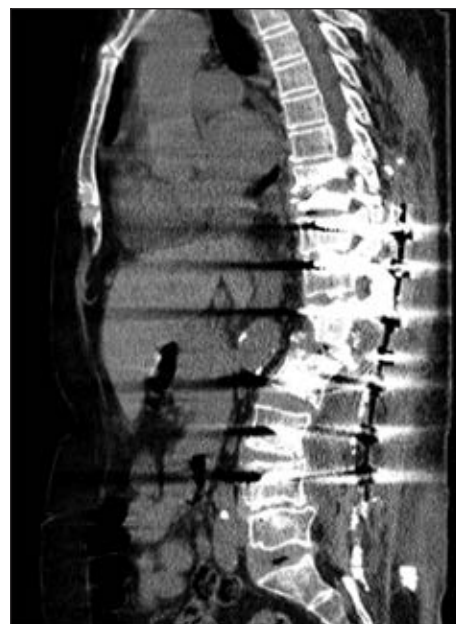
Sagittal MRI image of the patient in the postoperative period.
